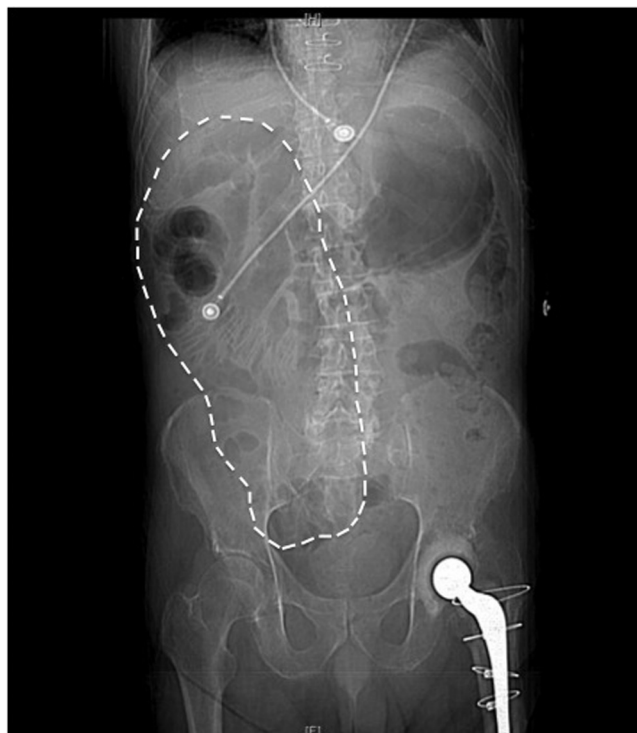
Abdominal X-ray demonstrates dilated loops of small bowel. A paucity of colonic gas is noted on the right side with a predominance of small bowel in right upper quadrant.
